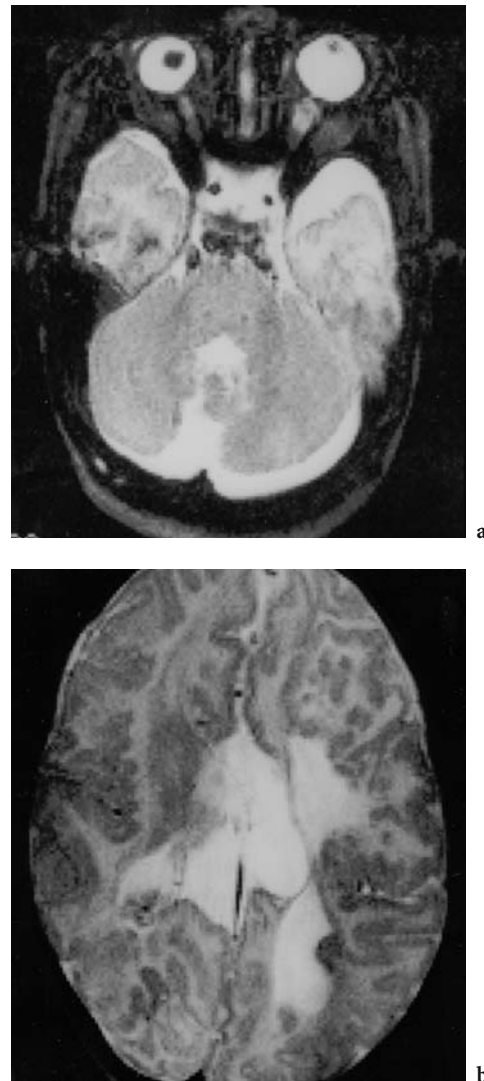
T2 axial MRI of a 3-month-old girl with AICARDI syndrome: bilateral (asymmetric) microphthalmos, vermiform hypoplasia, areas of polymicrogyria, multiple gray matter heterotopias, agenesis of corpus callosum and interhemispheric arachnoid cyst. (Reproduced with permission of Ferdinand Enke Verlag: BOLTSCHAUSER et al. 1992, Fig. 4)
